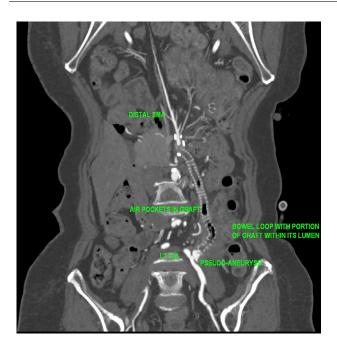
Sixty-one-year old female with abdominal pain. Findings: Coronal curved reformatted image of CT mesenteric angiography (arterial phase) demonstrates retrograde graft from left common iliac artery to superior mesenteric artery. Note: Lack of contrast opacification and presence of patchy air pockets within the graft and pseudoaneurysm.
